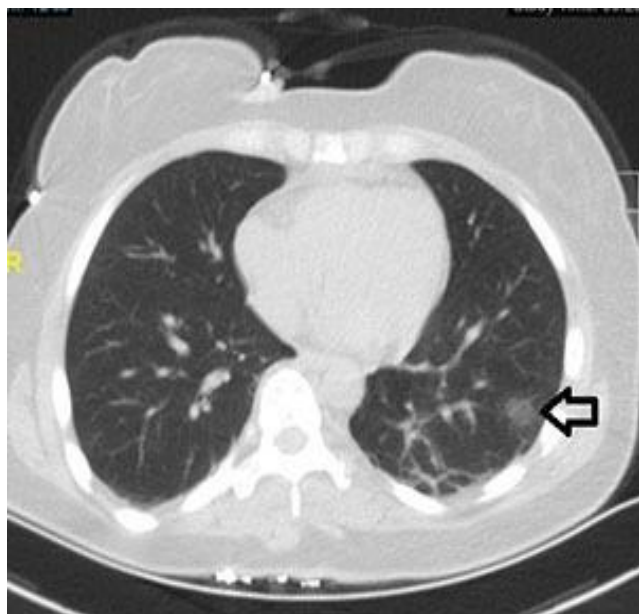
Axial non-contrast-enhanced thoracic computed tomography image in the parenchyma window shows area of infiltration with ground-glass density at the lower lobe of the left lung.
